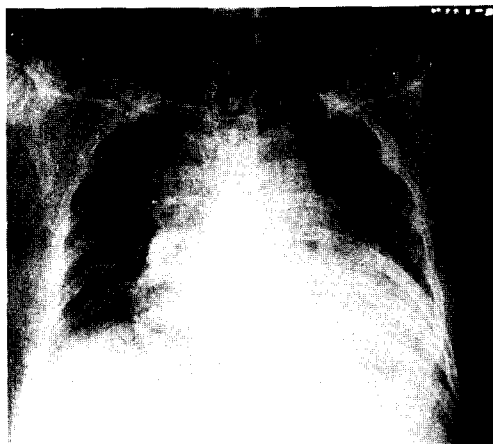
Roentgenogram of chest at admission.
